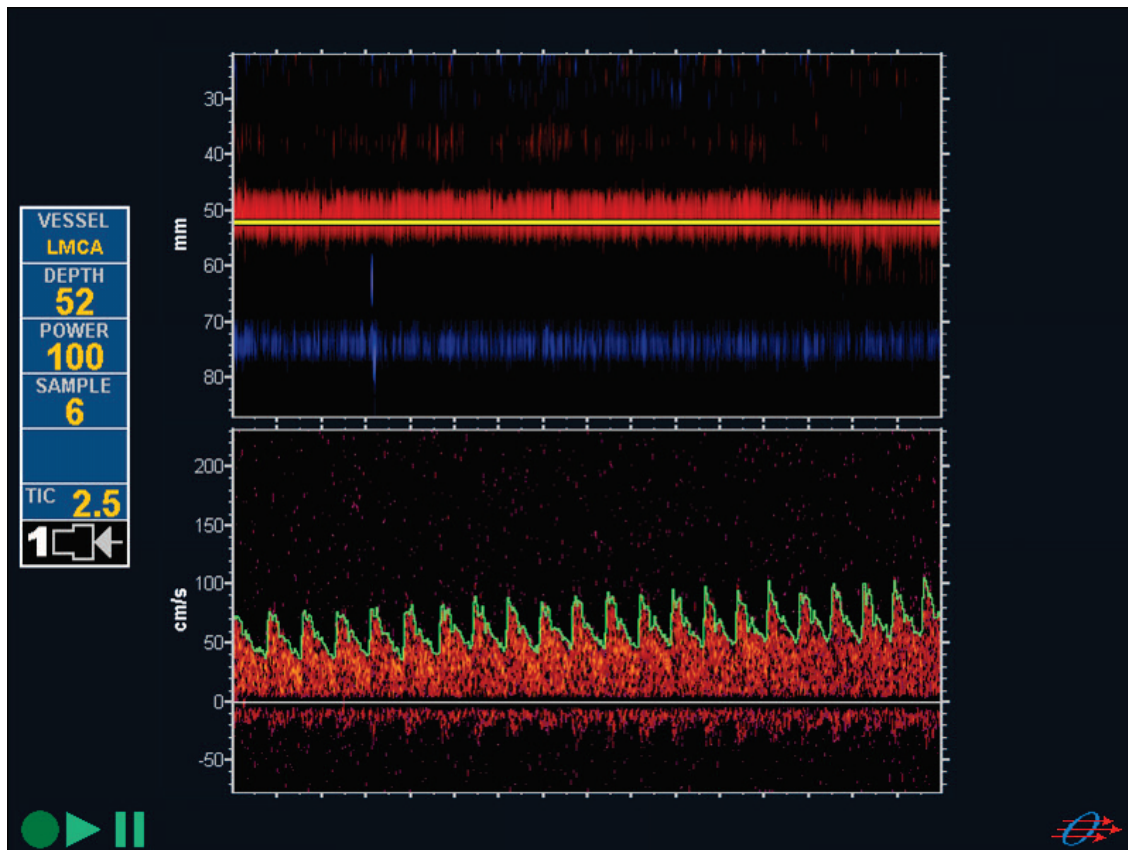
Transcranial Doppler ultrasound-monitoring of the left middle cerebral artery shows gradual increase of Mean Flow Velocities (from a baseline of 46 cm/sec to 61 cm/sec) during voluntary breath holding of 30 seconds.
